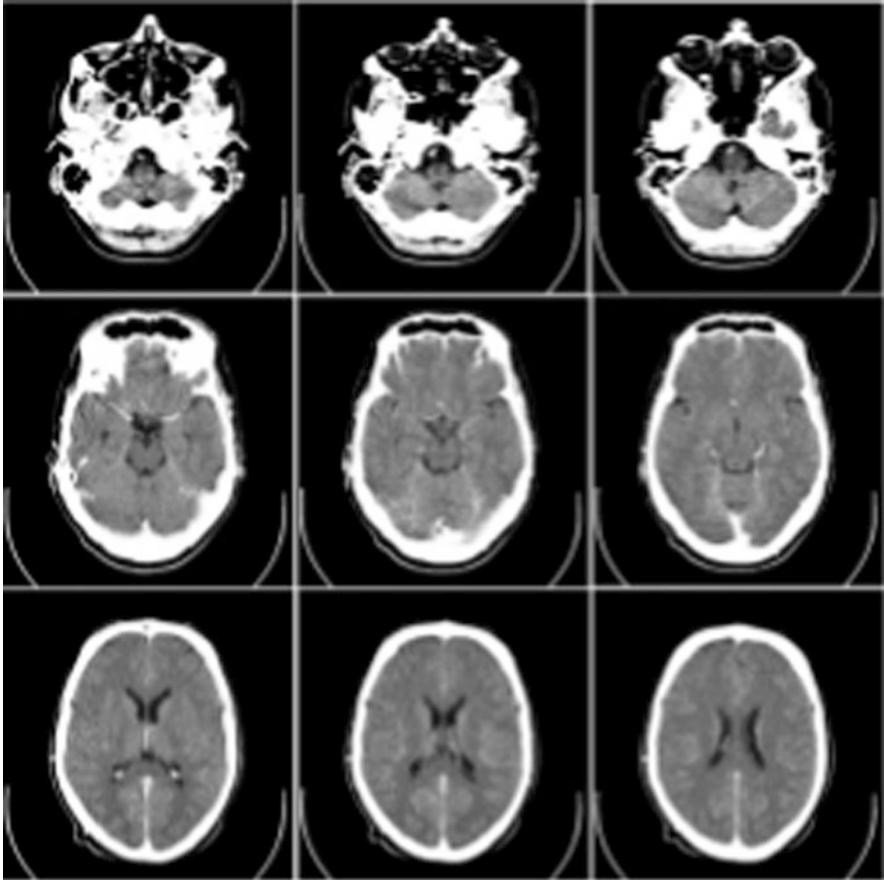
CT image of the skull showing different cross-sections (<http://pleasantonimaging.com/services/computed-tomography-ct/>)
